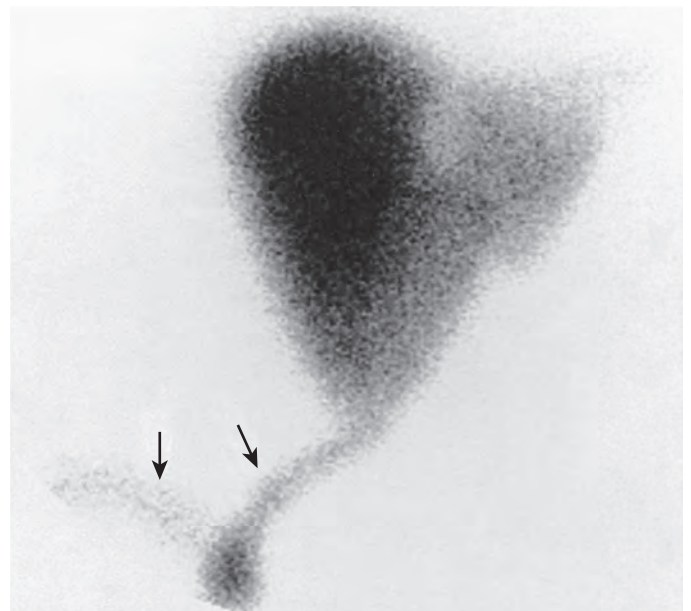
Biliary scintigraphy. This study demonstrates bile leak along the right upper quadrant drain (arrows) from a choledochojejunal anastomosis.
